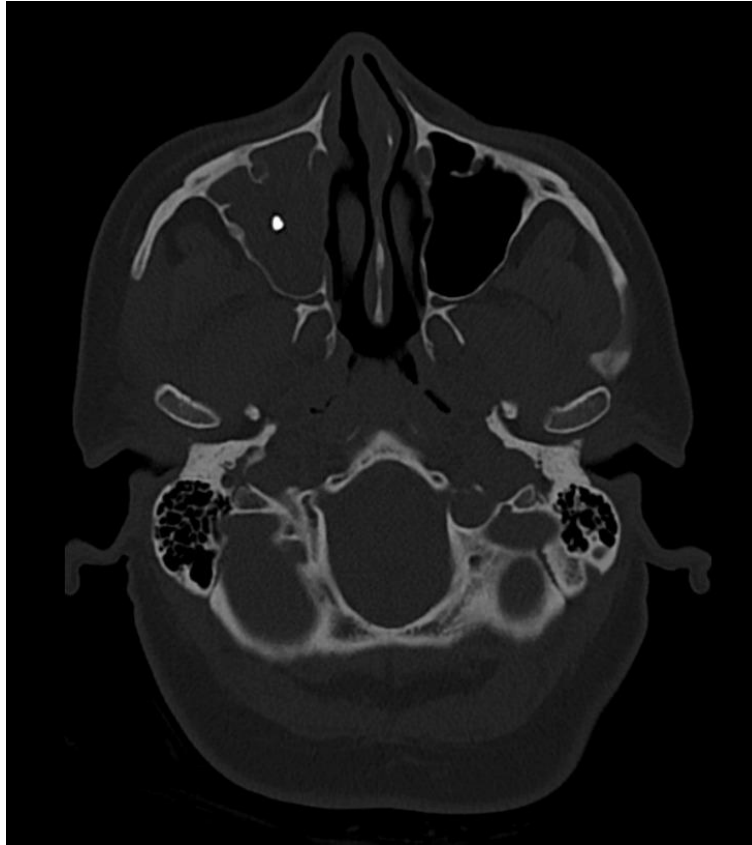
CT (axial section) of a patient with a foreign body of dental origin in the right maxillary sinus.
